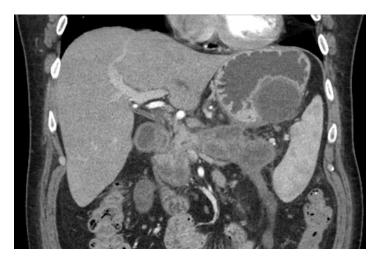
CT scan of the abdomen with extensive pancreatic necrosis, with a large amount of peripancreatic edema and several poorly organized fluid collections, the largest measuring $5.7 \text{ cm} \times 2 \text{ cm} \times 2.7 \text{ cm}$
